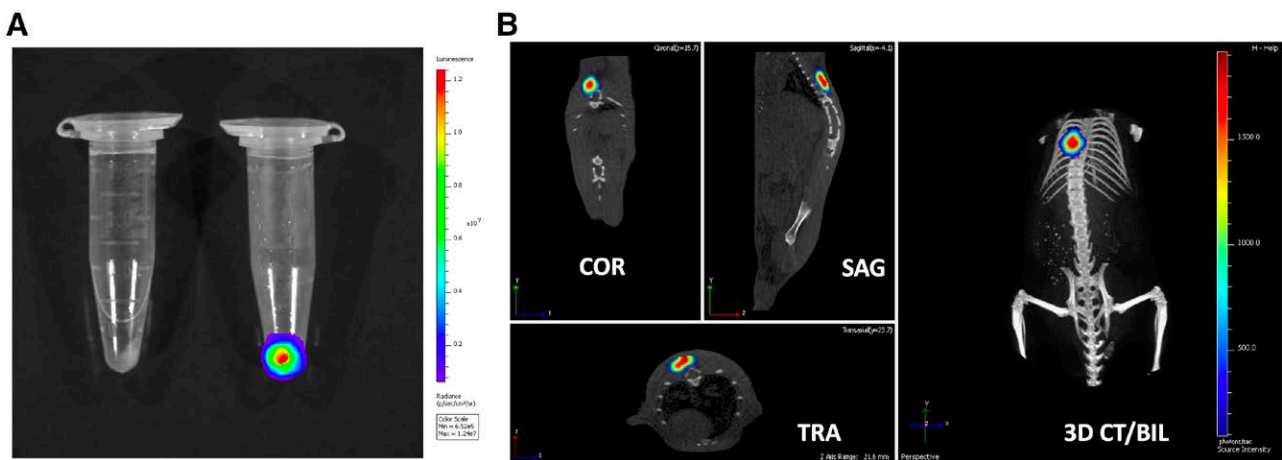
BLI of islet organoids in vitro and in vivo. A, BLI of islet organoids (25 IEQ) derived from control human-induced pluripotent stem cell (hiPSC-L1) without luciferase (left) and from luciferase expressing hiPSC-L1 (right). B, BLI reregistered with CT images of islet organoids graft in the BAT on day 14 posttransplantation (3D CT/BIL). BAT, brown adipose tissue; BLI, bioluminescence imaging; COR, coronal view; SAG, sagittal view; TRA, transverse view.
